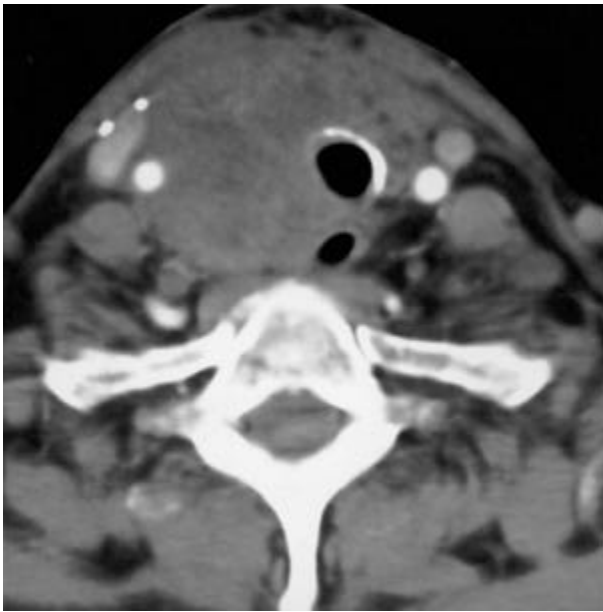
Postcontrast computed tomographic scan shows a 5×4-cm mass on the right lobe of the thyroid gland. This extends posteromedially towards the right side and is compressing the esophagus. The upper trachea is displaced to the left side.
